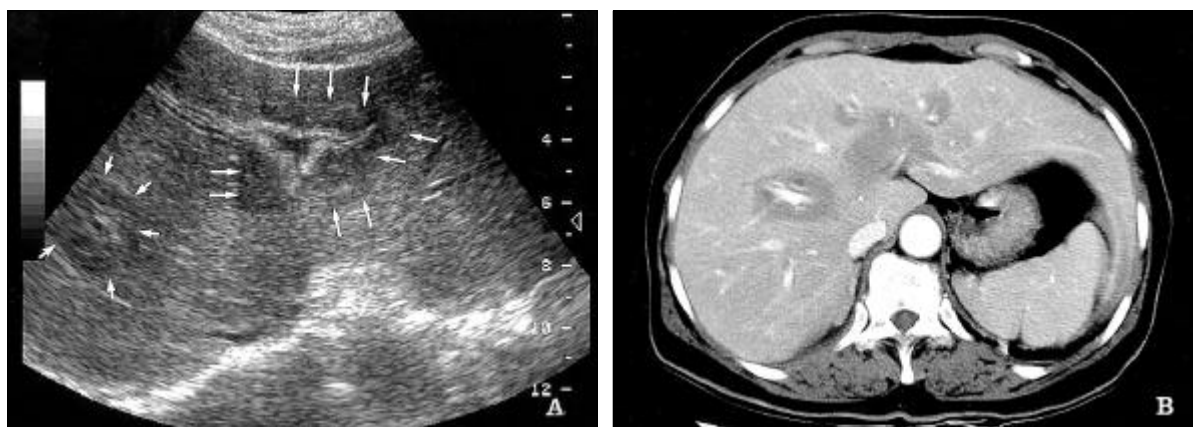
A. Abdominal sonography for evaluation of the possibility of obstructive jaundice shows an abruptly developed, slightly irregular, expanded, homogeneous, low echoic mass (arrows) encasing the portal system, without signs of the bile duct obstruction, which is the contiguous lesion in other images (not shown), as compared to the last sonography made nine days before. B. Contrast-enhanced abdominal CT scan performed just after the abdominal sonography shows the periportal encircling, homogeneously hypodense mass, with no regional lymphadenopathy or splenomegaly.
